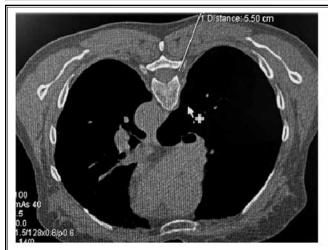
Representative CT images of positioning and placement during PRF treatment. (A) CT images of positioning during treatment. (B) CT images of placement during treatment.
